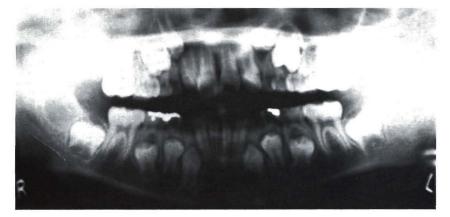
Panoramic radiograph of the patient showing bilateral malposition of the maxillary second premolars.
